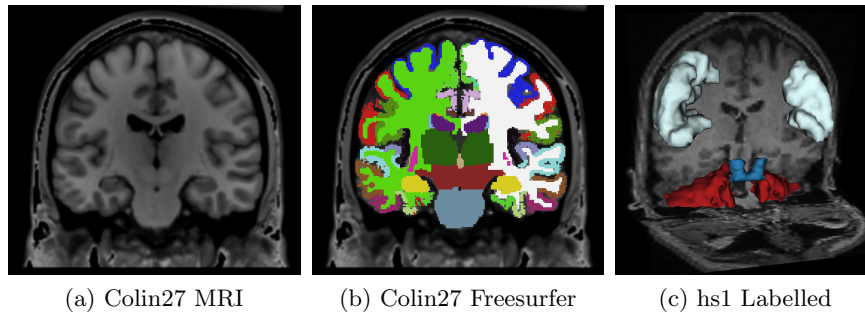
Visualizations of (a) Colin27 atlas MRI, (b) Freesurfer labels, and (c) a healthy subject with atlas-based labels (pre and post-central gyri, cerebral peduncles, and cerebellum), used for seeding and selecting tracts.
